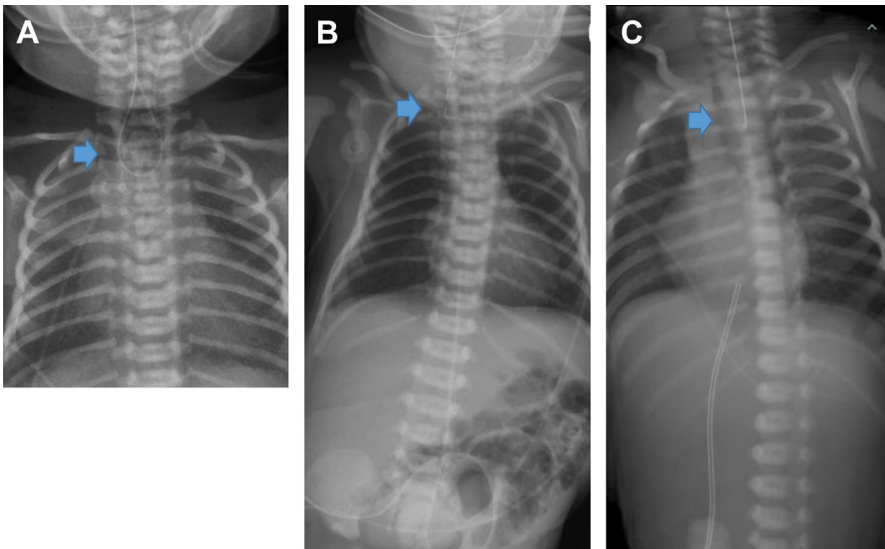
Plain radiographs in newborns with EA. (A) Nasoesophageal tube coiled in atretic upper esophageal segment. (B) EA with distal TEF, as suggested by the presence of intraluminal intestinal air. (C) EA without distal TEF, as suggested by gasless abdomen. Arrows denotes nasoesophageal tube location.
